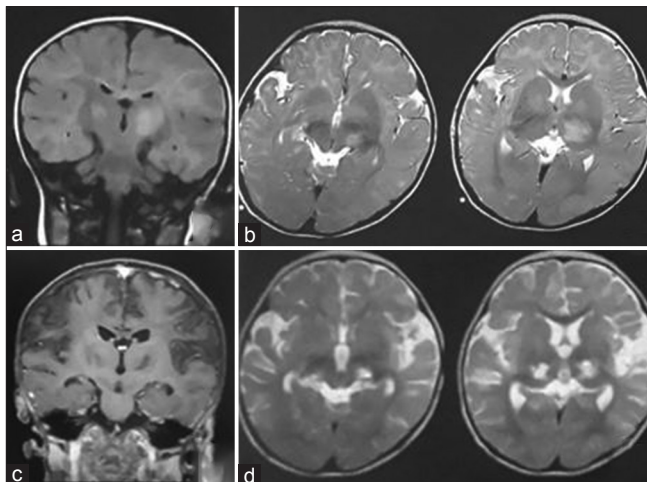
(a and b) Initial magnetic resonance imaging (MRI) of the brain; fluid-attenuated inversion recovery (FLAIR) and T2-weighted images (day 2 of illness) revealed asymmetrical abnormal signal intensity involving bilateral frontal, precentral, and central subcortical white matter, as well as deep gray and white matter, bilateral ventrolateral thalami, and in left midbrain. (c and d) MRI of the brain; FLAIR and T2 weighted images (day 28 of illness) revealing scarred cortices with large area of gliosis in bilateral frontoparietal perirolandic cortical and subcortical white matter as well as in bilateral thalamocapsular region
